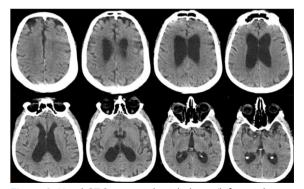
Head CT-Scan, serial axial planes (left to right sequence) - Global cortical atrophy without images suggestive of old cerebral infarcts in watershed areas.
